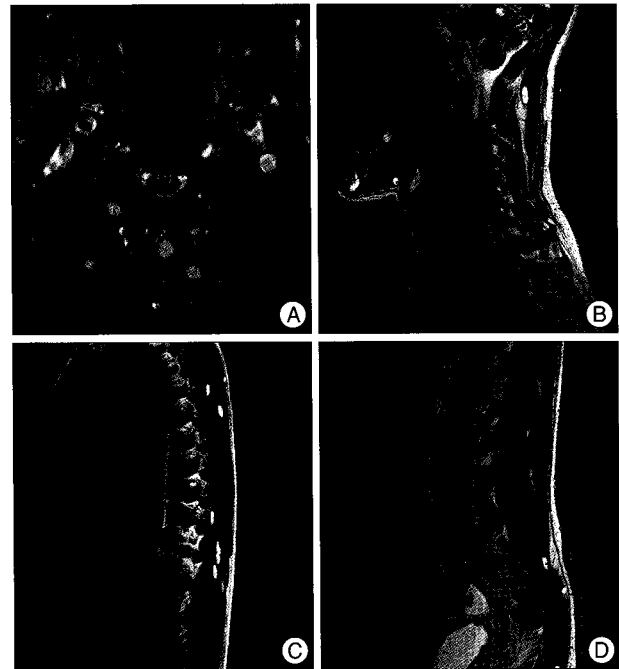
Spine MRI at admission. A and B : Spine axial and sagittal T1-weighted MR images without gadolinium show multiple cystic lesions in paraspinal muscle and cysticercus is seen in subarachnoid space on T3 body level. C and D : Spine sagittal, T2-weighted MR images without gadolinium show that numerous cystic lesions are also found in thoracolumbar spine muscle.
